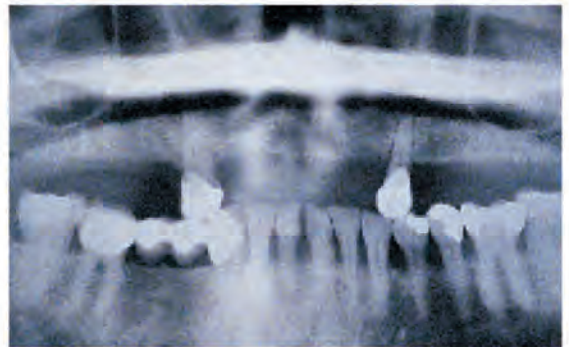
Panoramic radiograph of the remaining dentition.
